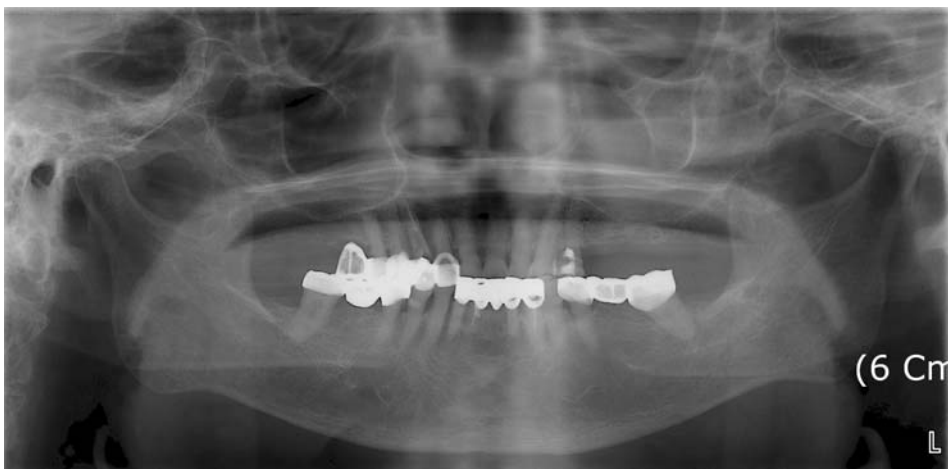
Panoramic radiograph shows cloudy opacity of the left maxillary sinus.
